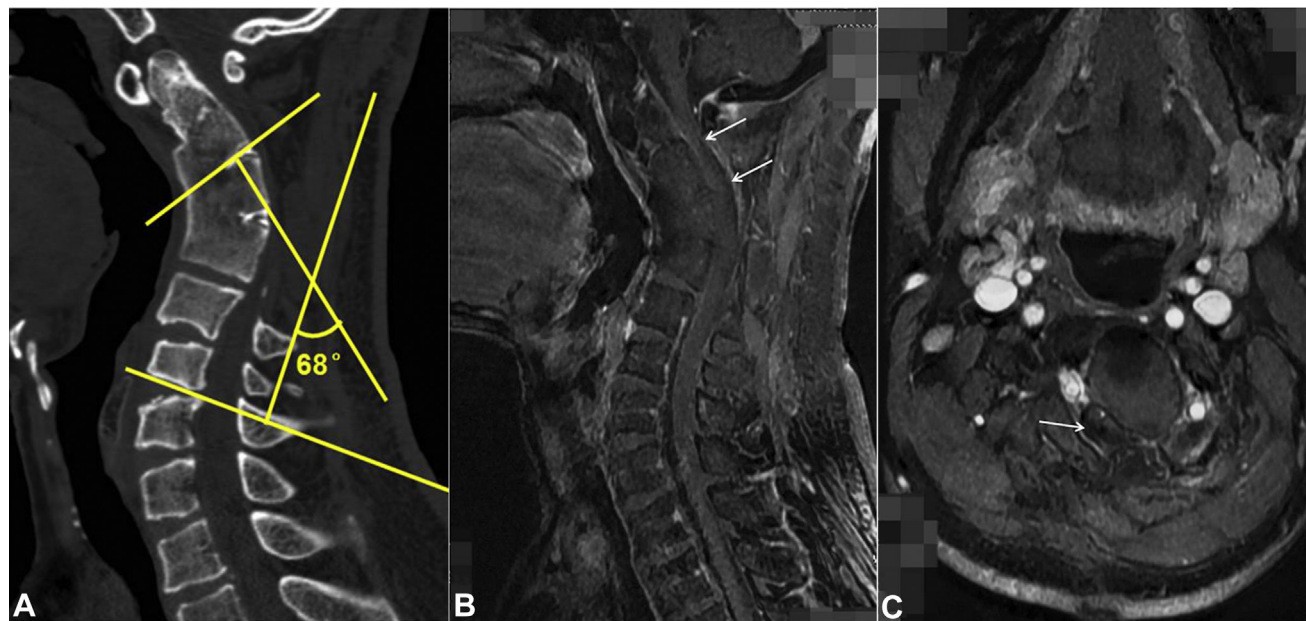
Preoperative computed tomography and magnetic resonance imaging. (A) Sagittal computed tomography image showing Cobb angle between C2 and C6 was 68°. (B and C) Magnetic resonance imaging showing severe spinal cord compression on C1-2 and C2-3 levels (arrows).
